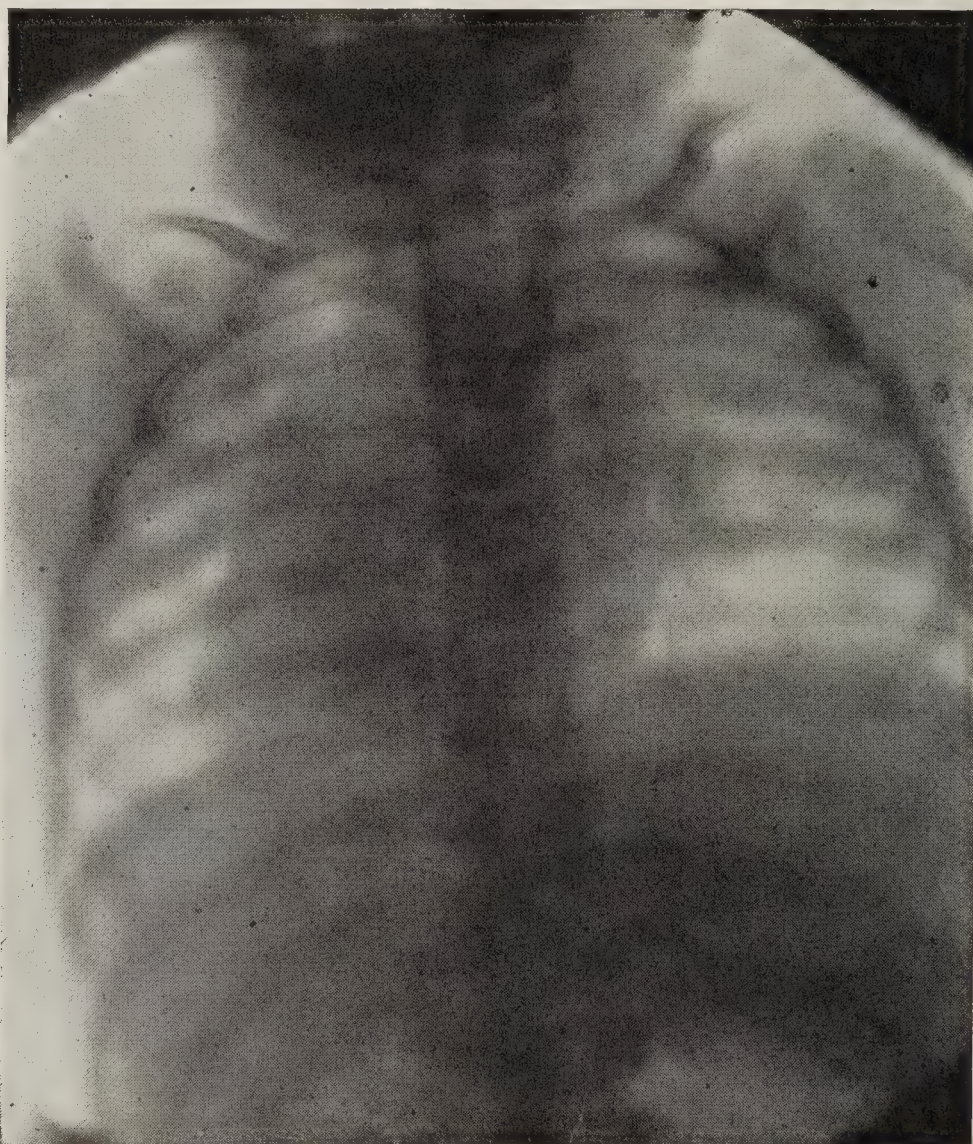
X-RAY SHOWS THYMUS SHADOW OF TWIN GIRL DESCRIBED IN FIG. 407.
